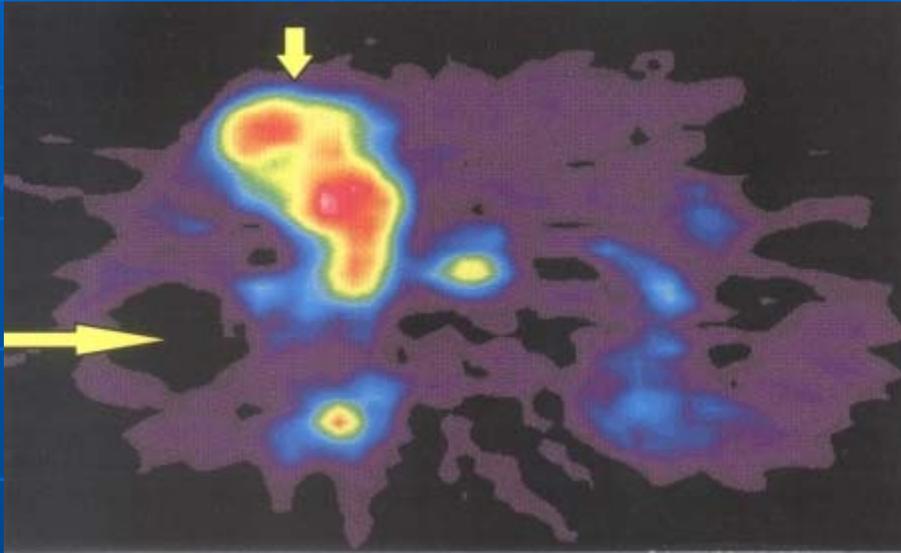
HTP-PET clearly demonstrating the high tracer accumulation in a minor part of the liver (short arrow), which by CT appeared to be almost totally replaced by tumour. The absence of tracer uptake in the tumour necrosis is also evident (long arrow).
